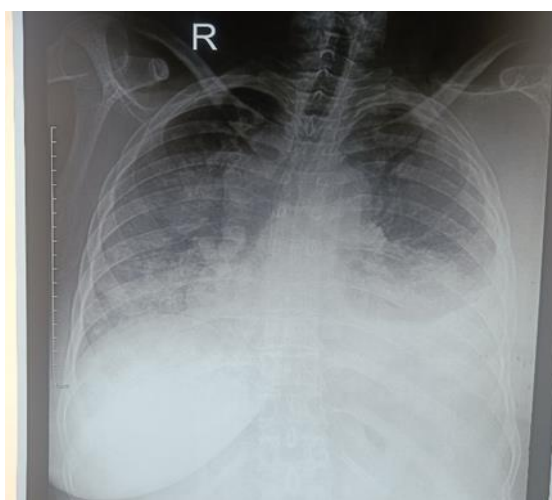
Chest X-Ray (PA View) showing bilateral pleural effusion and bilateral lung nodules
